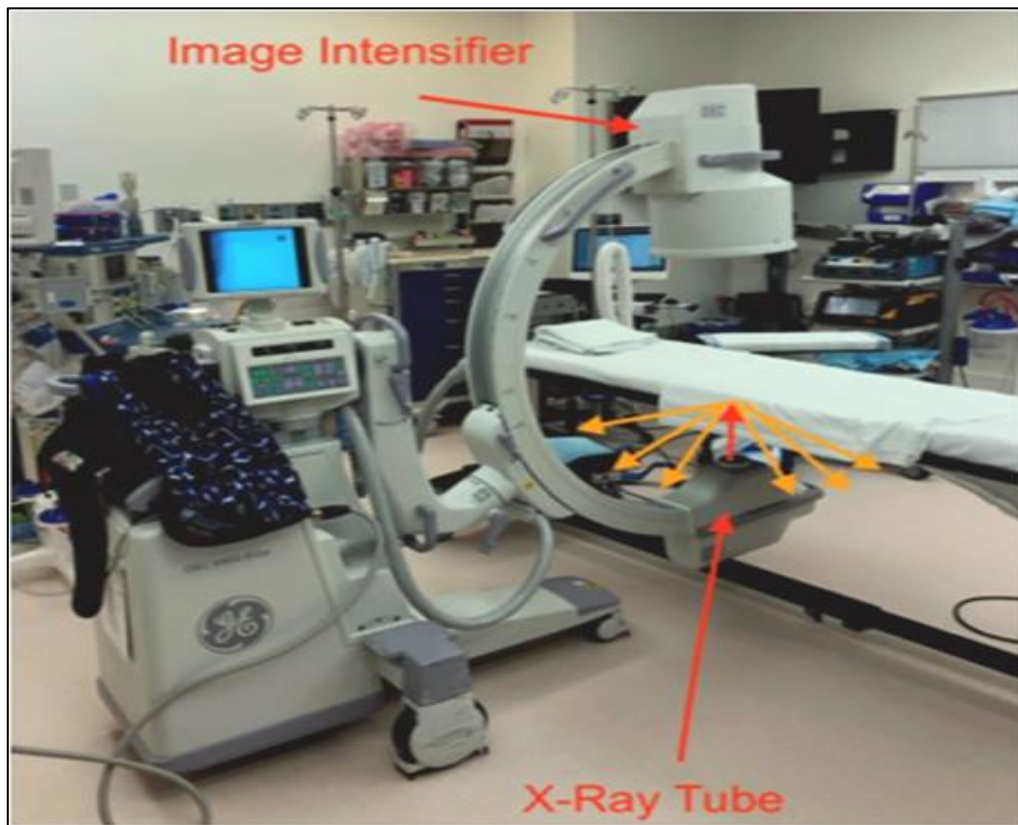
Correct positioning with the X-ray tube below the patient and table and the image intensifier above the patient.¹
